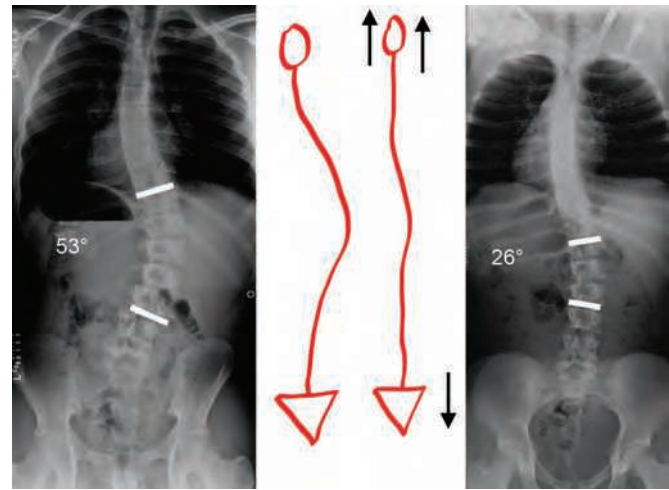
An example of the 'stretch' radiograph. A type 5 curve measuring 53° on erect radiograph (left), 'stretched' out to 26° (right), based on the principle of a gentle stretch of the trunk (center).
